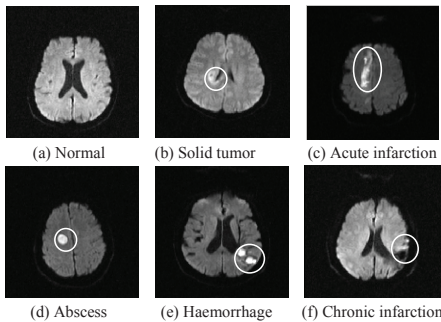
Original DWI with brain lesion indicated by a white circle
